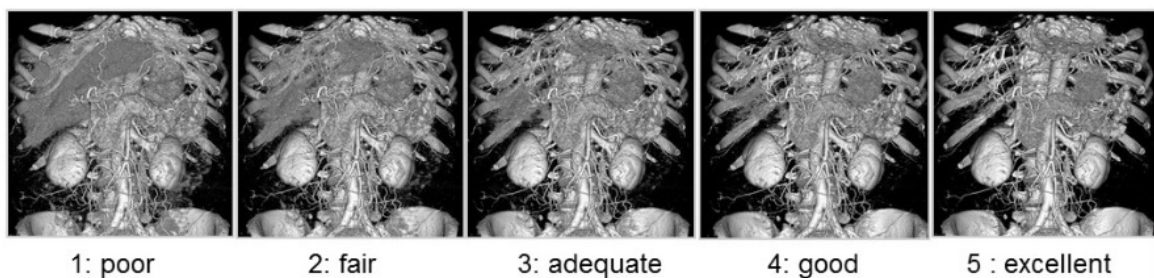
Evaluation figure of visual evaluation scores. Evaluation figure of visual evaluation scores. (1). In opacity curves with the same cut off CT attenuation, high level of noise decreases ease of vascular depiction and image evaluation. (2). Samples of 2D images of hepatic arterial phase of each protocol. Lowest level of noise in protocol C (IMR). Measurement of ROI with the 2D image indicates highest CNR value with protocol C (IMR). (3). Samples of 2D images of hepatic portal phase of each protocol. Lowest level of noise in protocol C (IMR). Measurement of ROI with the 2D image indicates highest CNR value with protocol C (IMR). (4). Mean 3D image quality evaluation score value. Significantly higher image quality of hepatic artery and portal vein with protocol C (IMR). (5). Samples of 3D images of hepatic arterial phase of each protocol. With the 3D image under same opacity curve, image quality of the hepatic artery was highest with protocol C (IMR), with a high CNR value and low level of noise.
